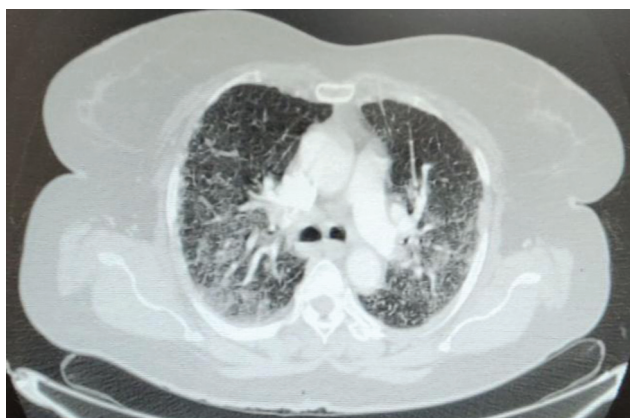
Computed tomographic image of the chest demonstrating numerous perilymphatic nodules and peribronchovascular opacities.
